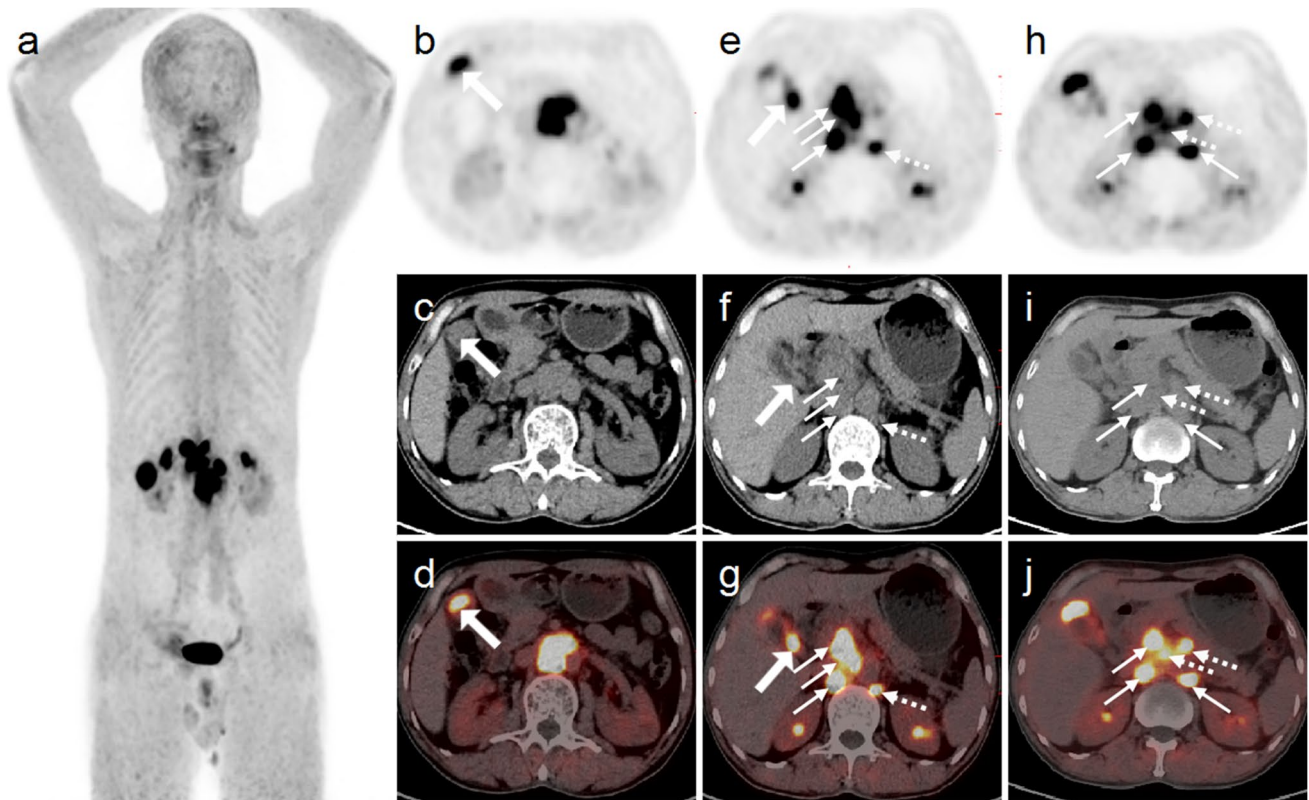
In ^{68}Ga -FAPI-04 PET/CT, the MIP of PET (a) showed more lesions with high uptake of FAPI in the upper abdomen than ^{18}F -FDG PET/CT. In the corresponding axial fusion images (b–j), intense ^{68}Ga -FAPI-04 uptake was also noted in the above FDG-avid
